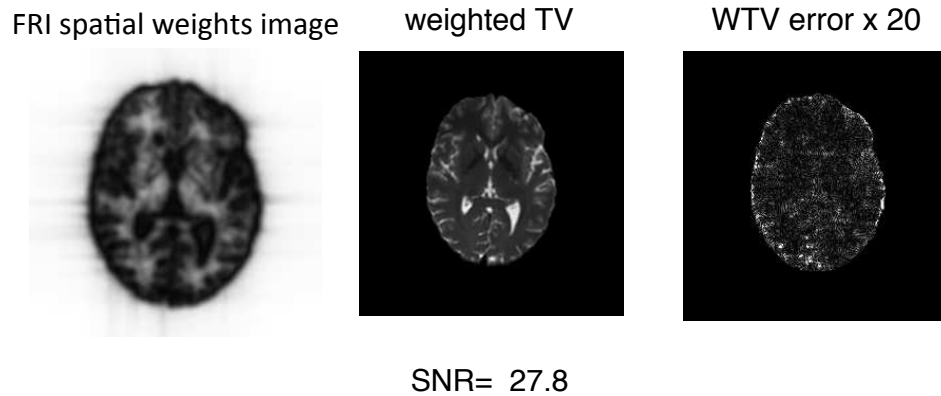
Reconstructed b0 component of a typical DWI subject using FRI edge map suggest in (Ongie and Jacob, 2015).
